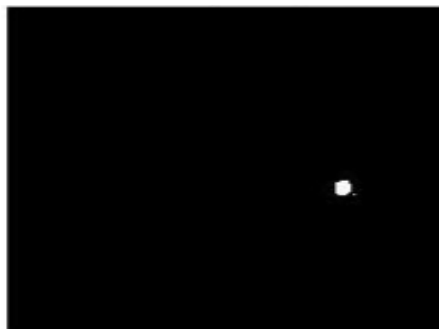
Extracted Lung tumour From the Segmented Binary Image of CT Image
